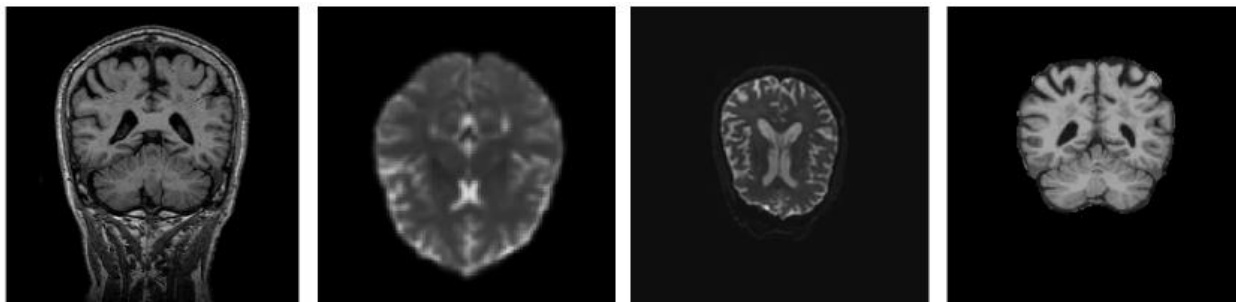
MRI images from OASIS dataset (*open-access public database*) [24]: (a) non-demented aging disease, (b) high-grade mild dementia, (c) mild dementia disease, (d) less extreme dementia disease, (e) Alzheimer's Disease (AD), and (f) healthy control (HC).
